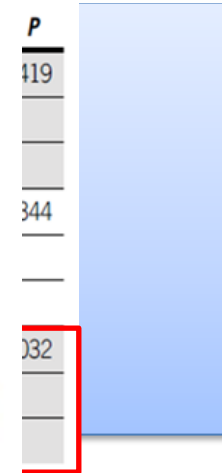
Effect of lateral lymph node dissection (LLND) on lateral local recurrence in patients with a short axis ≥ 7 mm on pretreatment magnetic resonance imaging in patients who received (chemo)radiotherapy.
